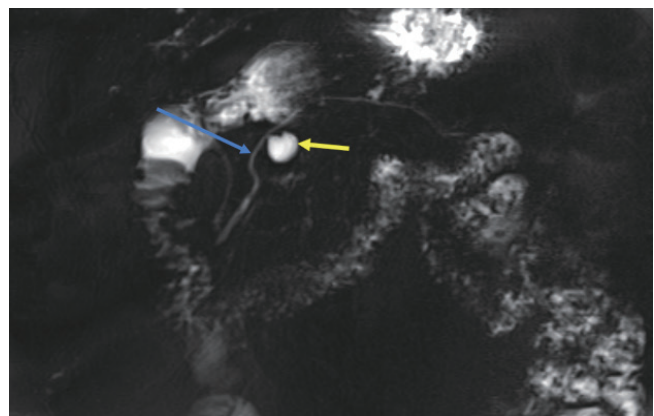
Coronal heavily T2 weighted MR cholangiopancreatography image of a 75-year-old male demonstrates a cystic lesion (yellow arrow) in the body of the pancreas, connecting to the main pancreatic duct (blue arrow), consistent with branch duct-type intraductal papillary mucinous neoplasm measuring 1.3 cm. Based on imaging, this does not meet the criteria for an endoscopic ultrasound with fine-needle aspiration, thus no pathologic diagnosis has been rendered.
